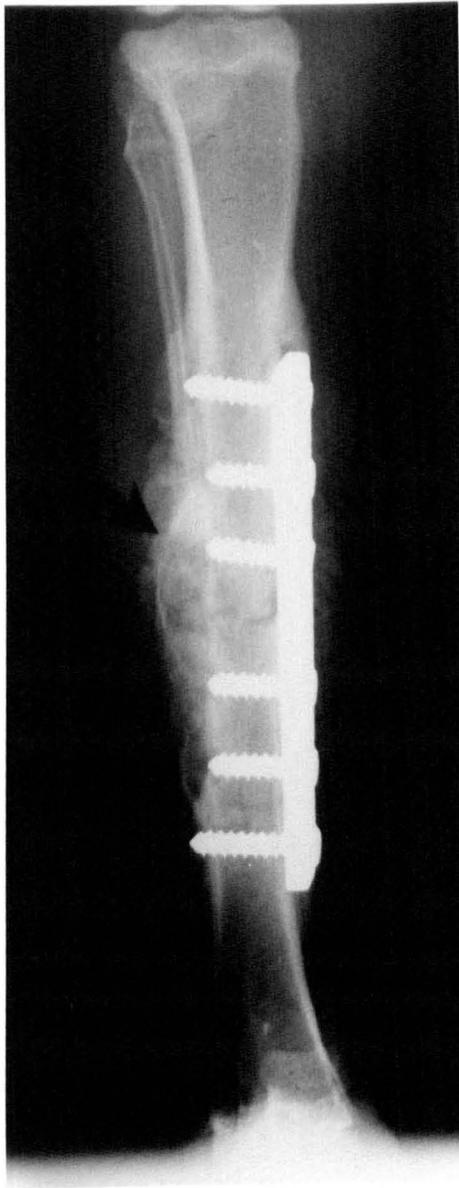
Radiograph obtained six weeks after fixation with a dynamic compressin plate and inoculation with bacteria. This shows extensive periosteal reaction, limited to around the plate. The fracture site is still visible.
